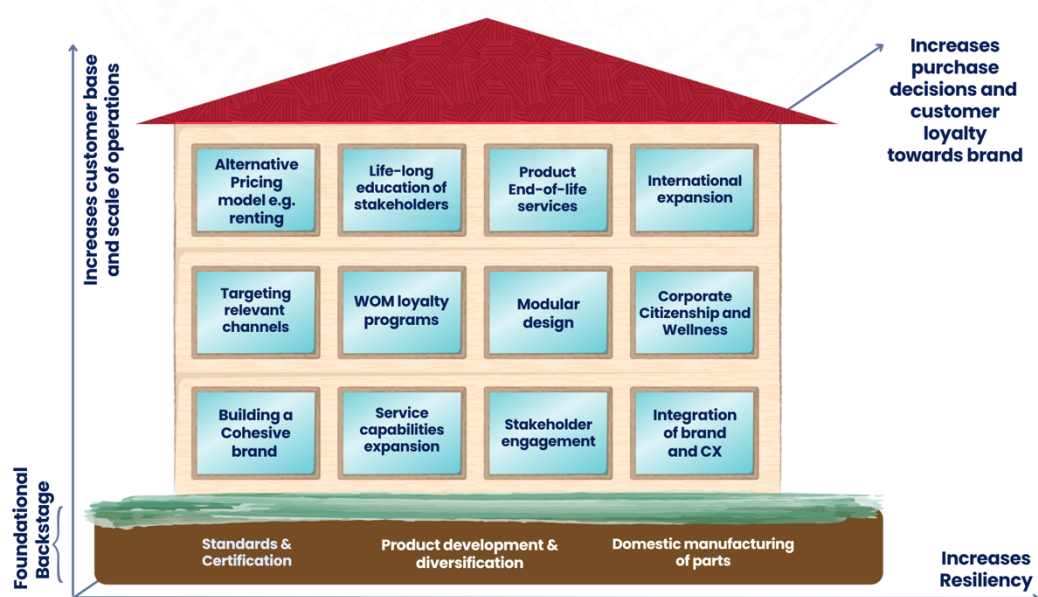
Proposed Framework for Developing Thai Dental X-ray Brands
